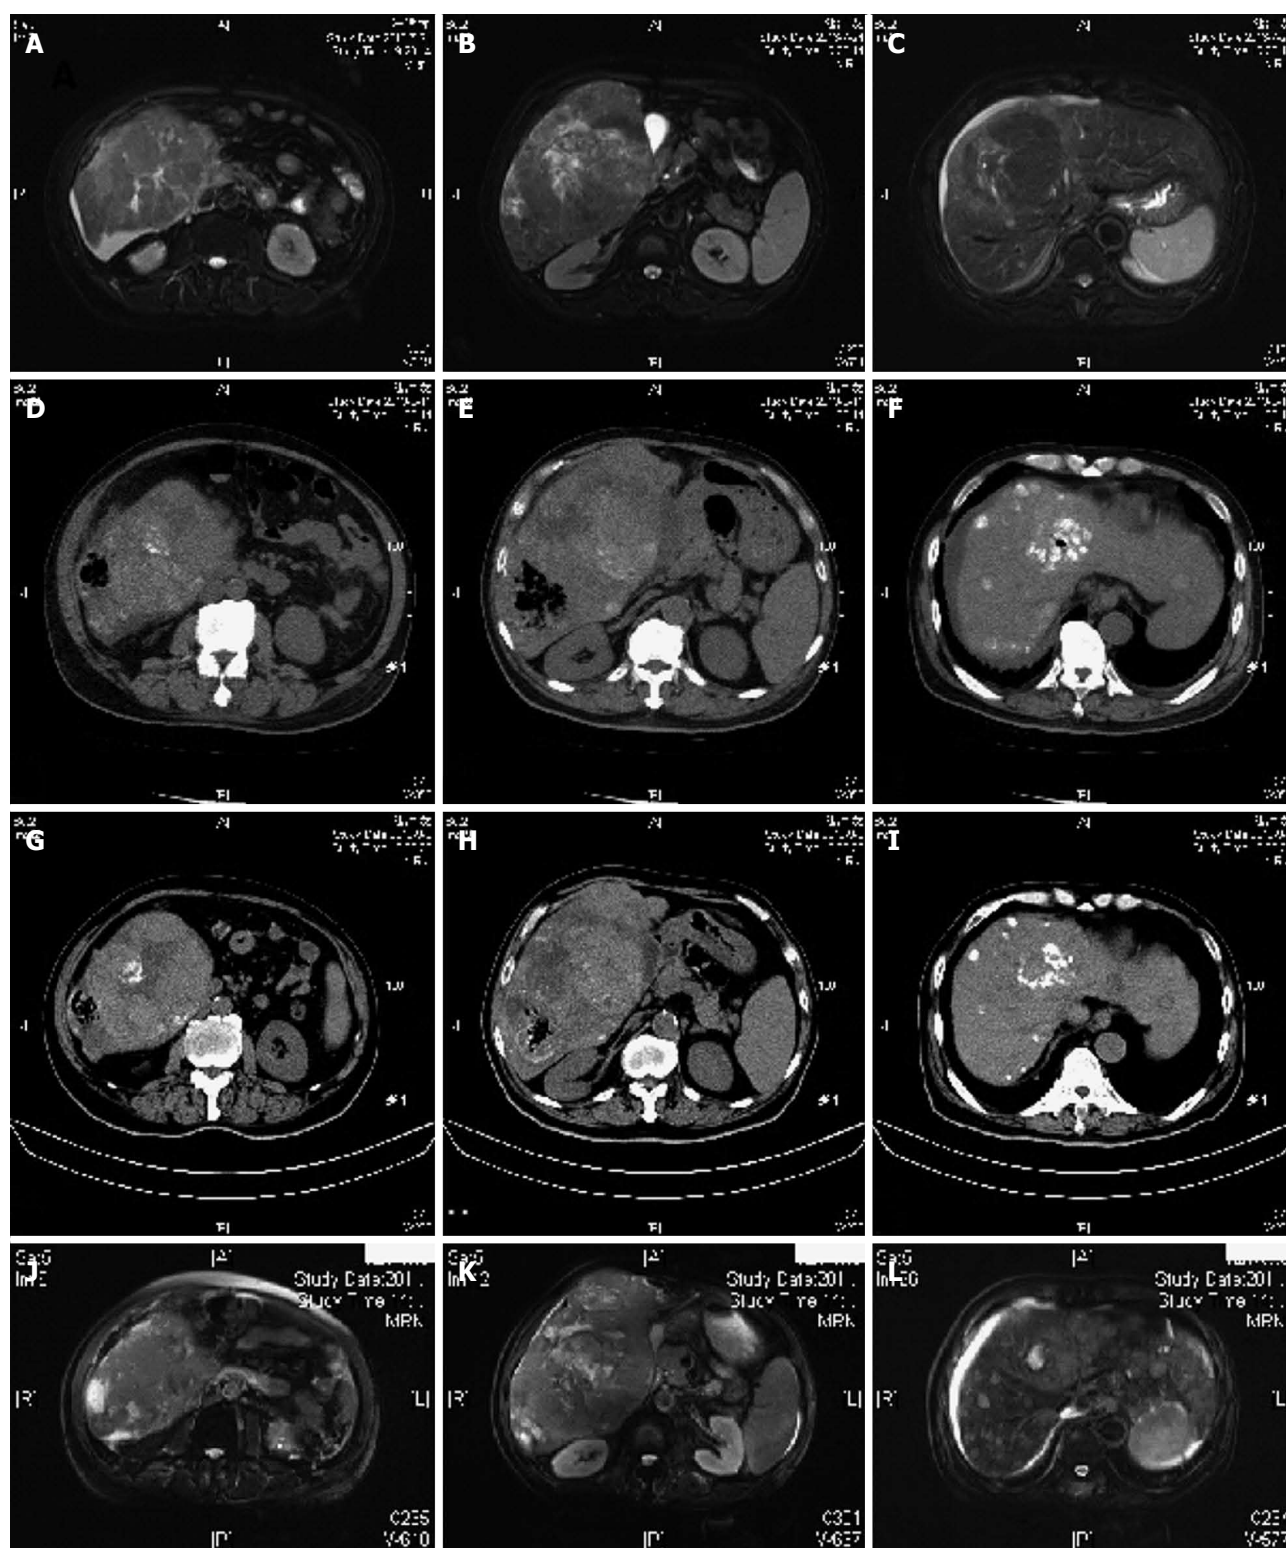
Magnetic resonance imaging and computed tomography findings. A-C: Magnetic resonance imaging (MRI) images before transcatheter arterial chemoembolization (TACE); D-F: Computed tomography (CT) images showing a gas-forming liver abscess when the first TACE was done; G-I: Five week after the first TACE procedure, CT image showed that the gas-forming liver abscess became smaller; J-L: Eleven week after the first TACE procedure, MRI showed no obvious liver abscess.
